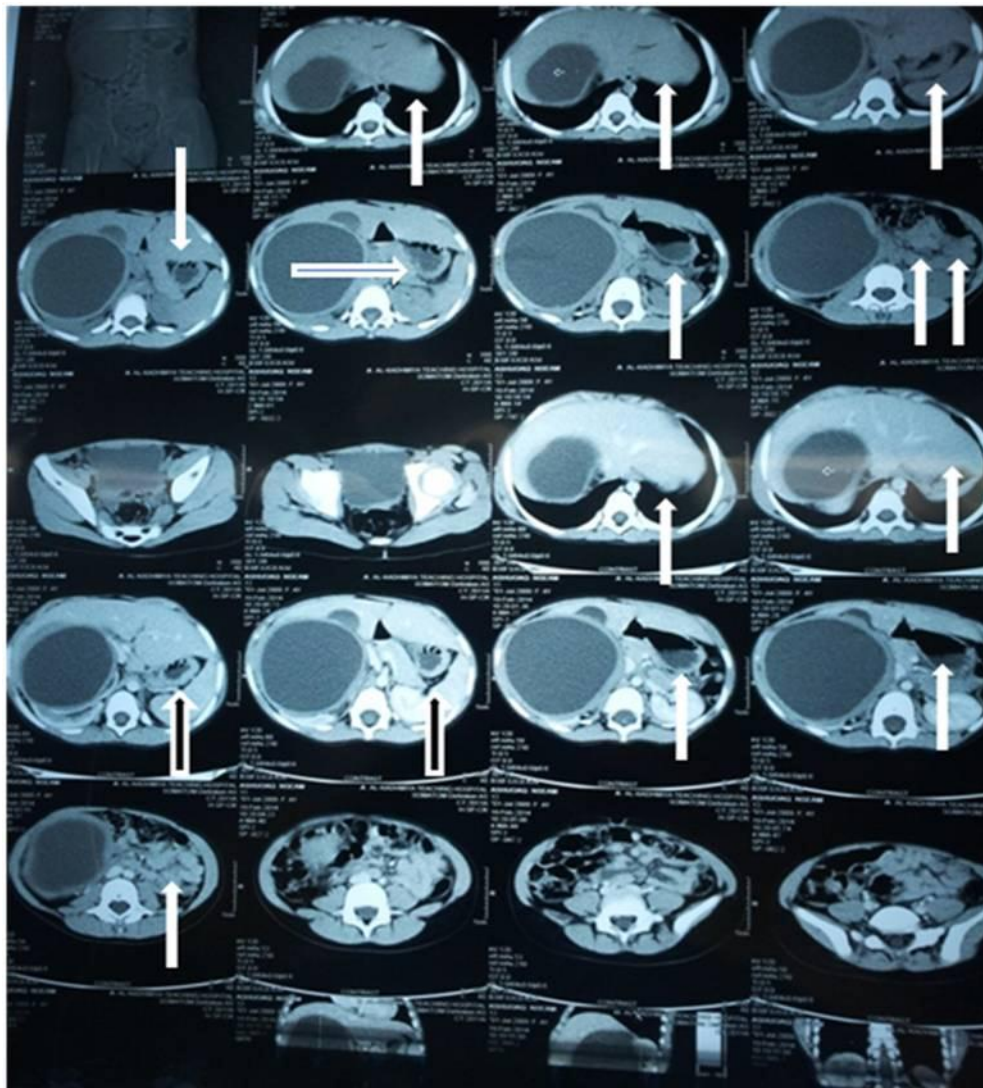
CT-scan of abdomen showing a big retroperitoneal Hydatid cyst (arrows showing a huge Hydatid cyst)
